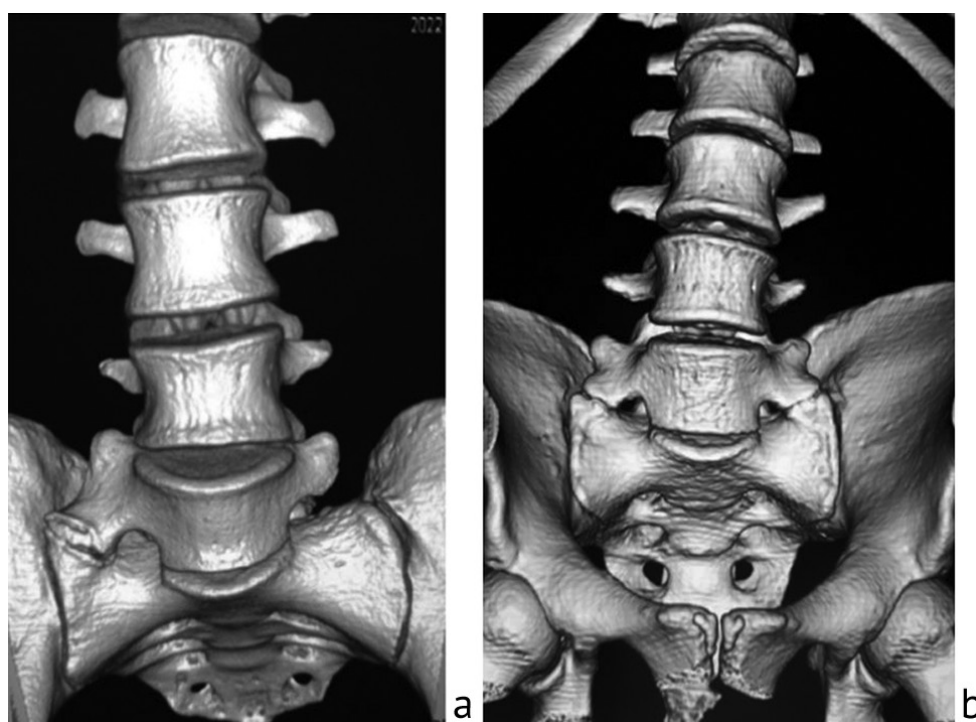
CT scans of the lumbar spine and sacrum of 17-year-old patients: transitional (sacralized) lumbosacral vertebrae, type IIa (a) and type IIb (b), authors' clinical observations
